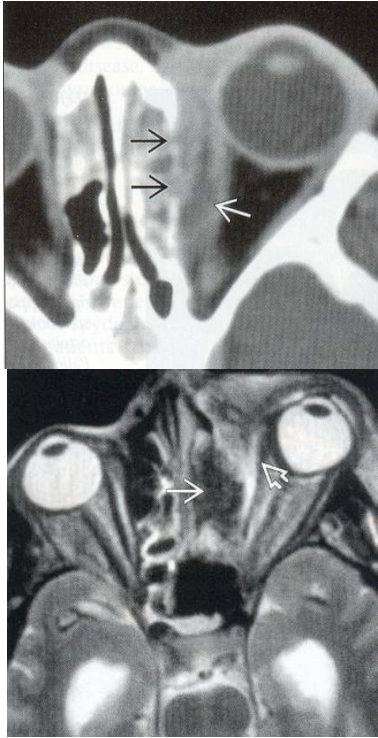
CT & MRI scan of orbit, axial view. Inflammatory process in left ethmoid sinus extending into the left orbit causing Proptosis.
